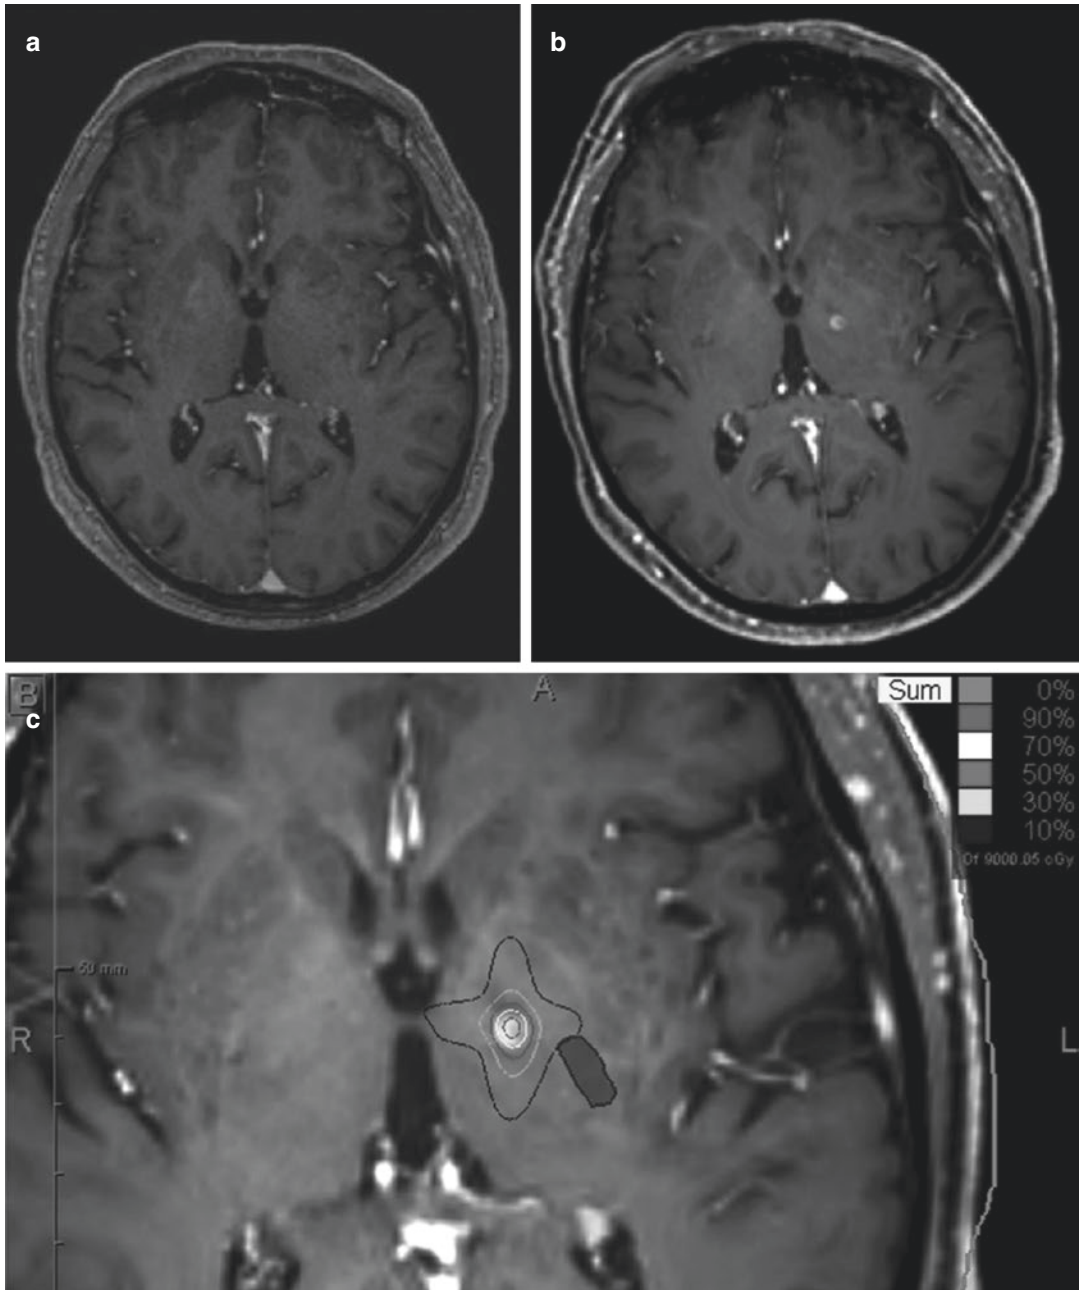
A pre-treatment image (a) together with an 18 months post-treatment image (b) are represented here. The post-treatment MRI fusion with the treatment plan
